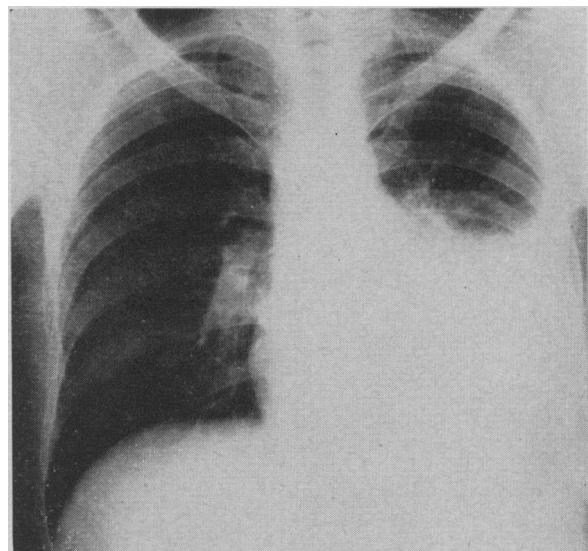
Admission chest radiograph
